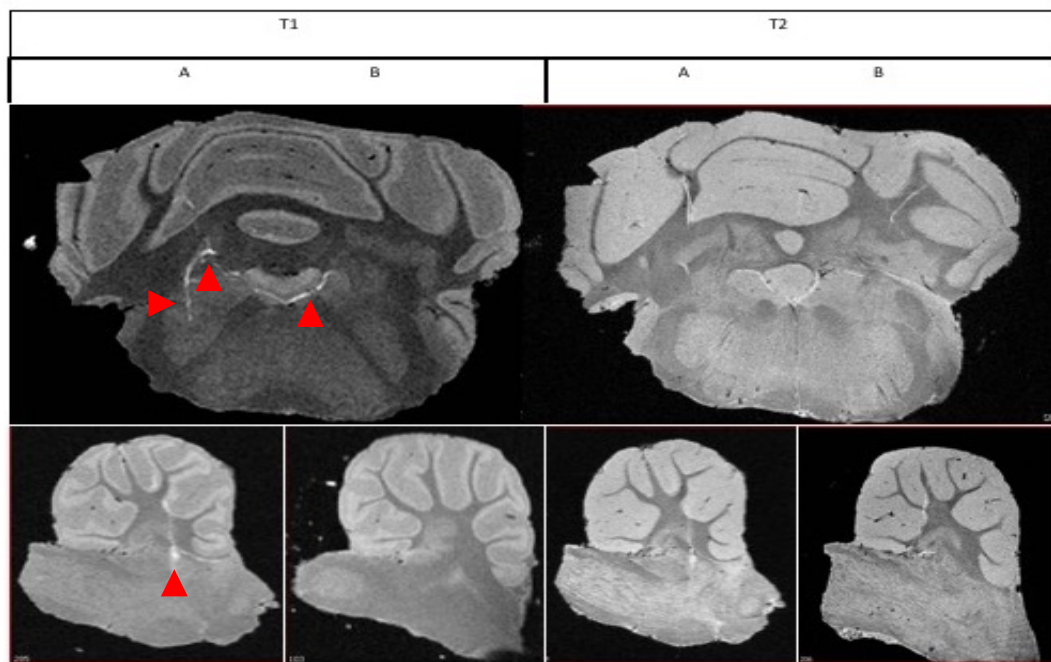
Ex vivo MRI of transplanted cells with improved technique and image sequences. Fixed HEK cells expressing OATP(A), and sham infected cells (B) injected in to fixed tissue. The 'lightening bolt' distribution can be seen on the T_1 sequences. The top panel shows the cerebellum in transverse section, the bottom panels show the corresponding right and left sagittal images with the slice positioned over the injection site (A), and the anatomical equivalent on the contralateral side of the cerebellum. The T_2 panels show the cells are isointense to the tissue as would be expected. Red arrow heads highlight the contrast enhancing cells on the T_1 sequence images. T_2 images were acquired using the following parameters: TE 11.94ms, TR 60ms Flip Angle 15 degrees 70us gauss, 8 acquisitions, 1 average per acquisition T_1 images were acquired using the following parameters: TE 3.82ms, TR 11.0ms, Flip Angle 90 degrees, 70us gauss 32 acquisitions, 4 averages per acquisition.
